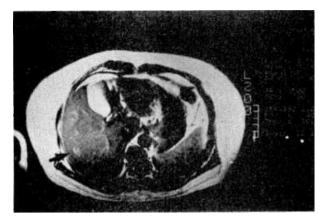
T2-weighted (2500-30) axial MR image displays relatively high intensity (arrow) compared to the background liver tissue.
